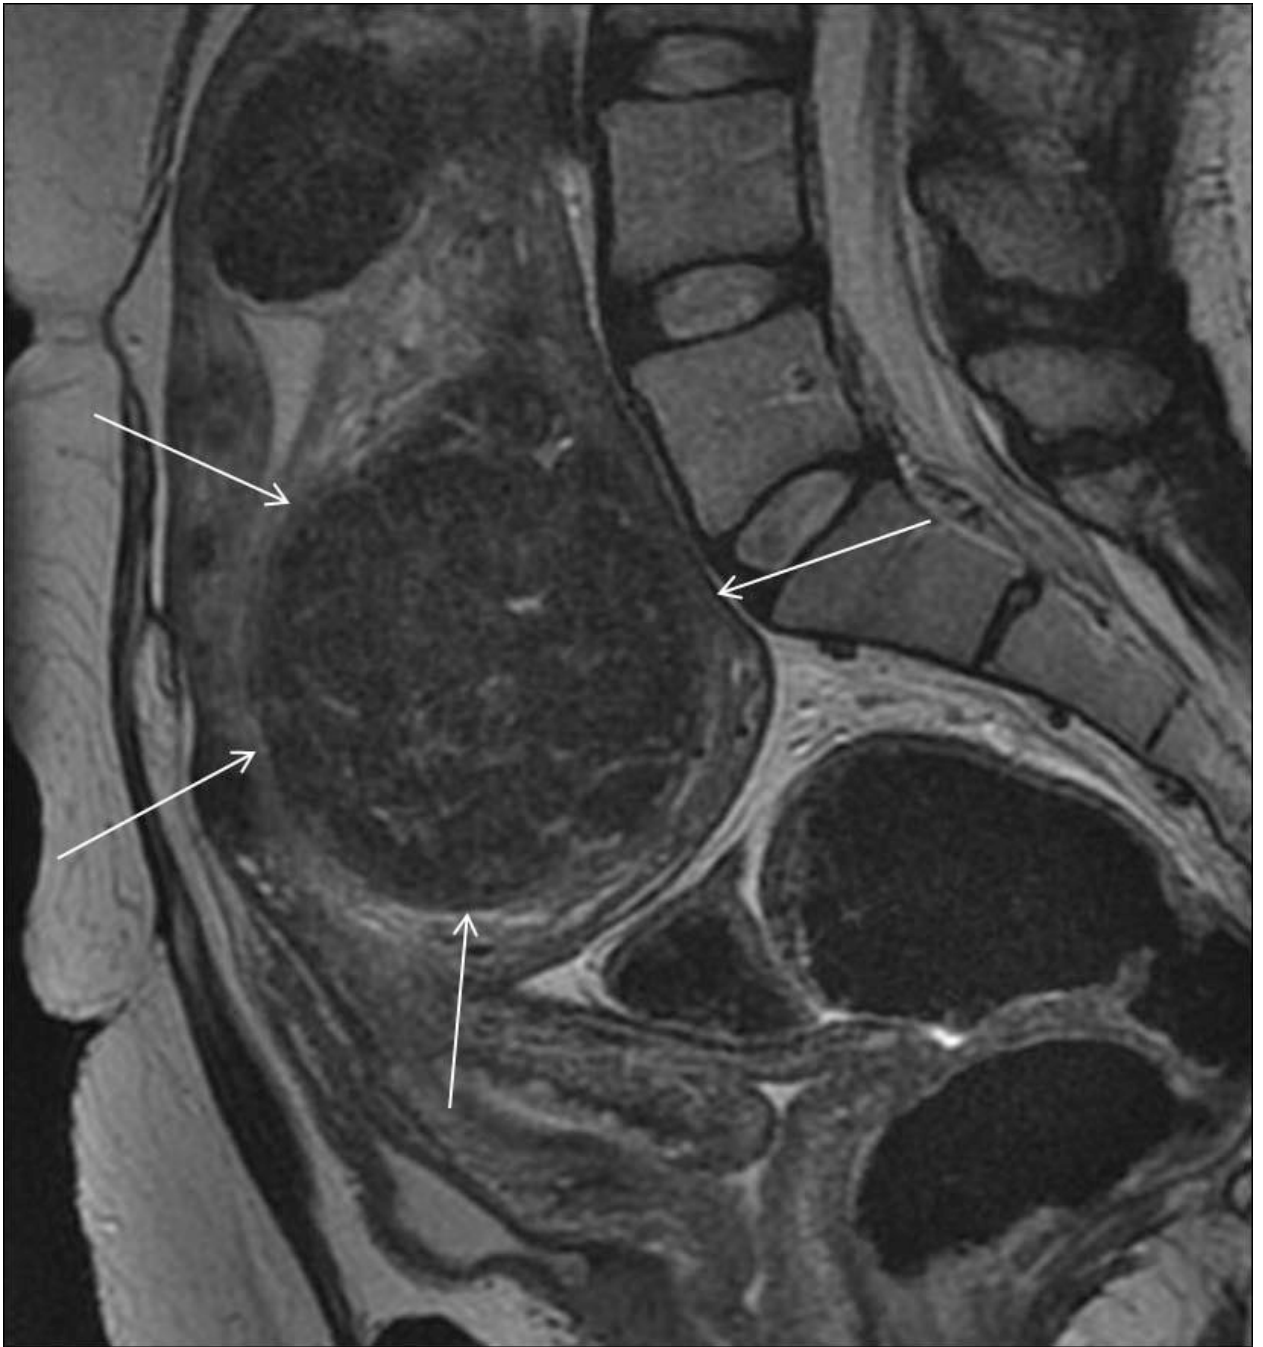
Classic uterine fibroid. On T2 weighted sagittal MR imaging, uterine fibroid (arrows) shows characteristic homogeneously low signal intensity.
